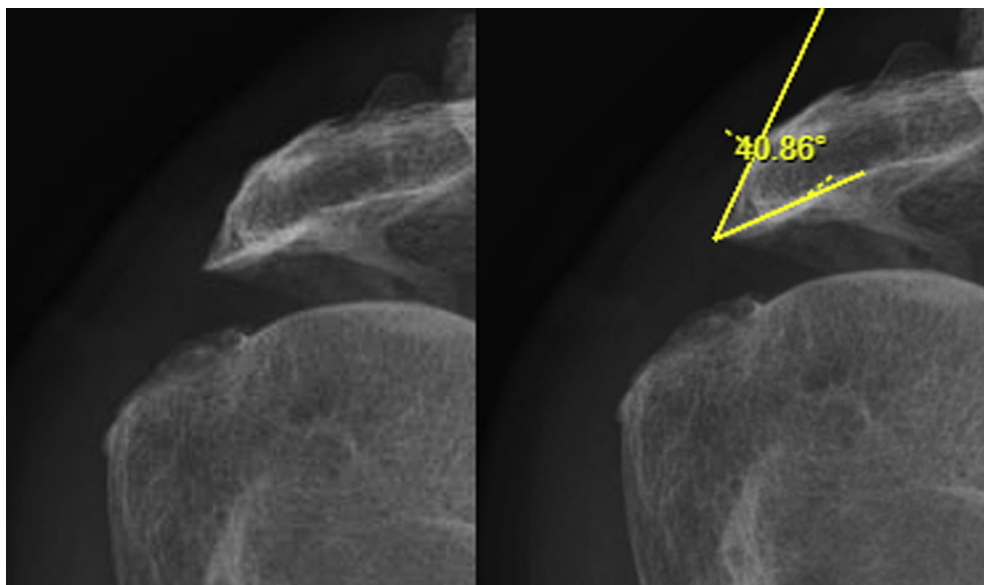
Radiographs of glenohumeral joint showing the assessment of infero-lateral acromion angle (ILAA) which measures 40.86° . It is measured between a line along the inferior border of acromion starting from the most inferolateral point and another line connecting the most inferolateral point to the most prominent point on lateral border of acromion.
